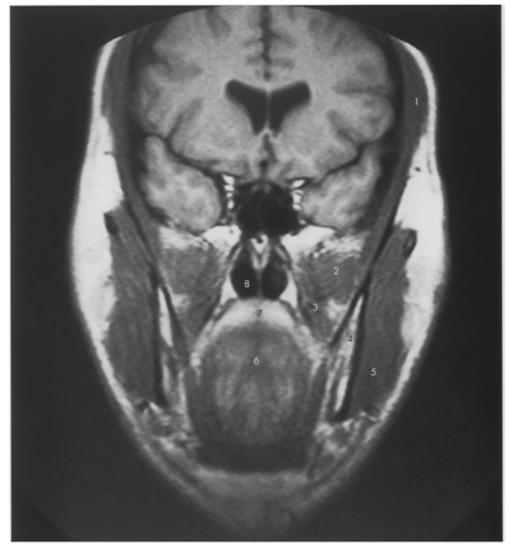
Coronal MRI scan of the head towards the back of the ramus.
